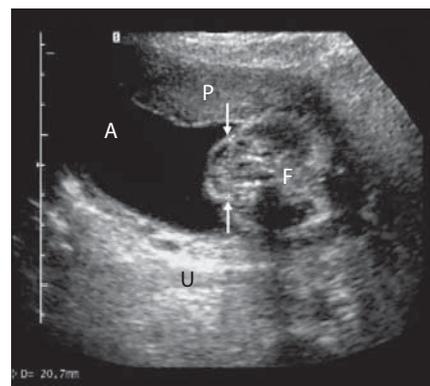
Ultrasound image of a fetus (F) with a large sacral MMC (→) in the 17th week of gestation. Axial plane. P = Placenta; U = uterus, A = amniotic cavity.
